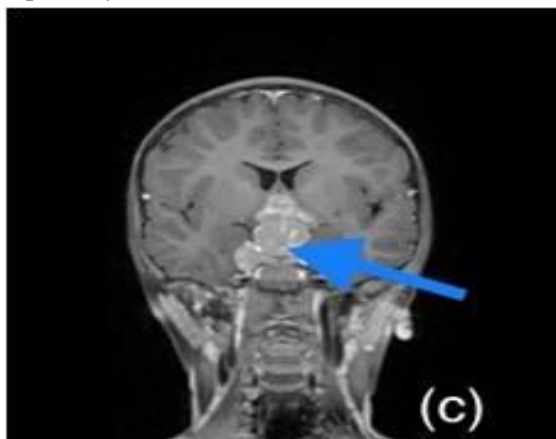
MRI T1 - post contrast images showing: (a) Sagittal view showing well lobulated lesion arising from pituitary gland compressing optic chiasm and corpus callosum (arrow).
